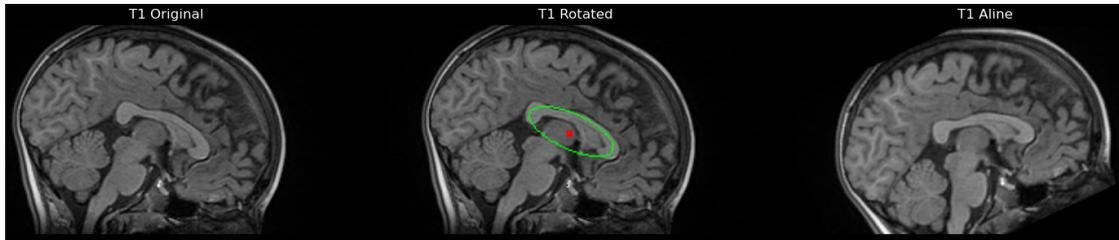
Midsagittal plane of T1-weighted image. Note how the corpus callosum is aligned with the horizontal axis by capturing the anterior-posterior axis of this structure with an ellipse fitting.
